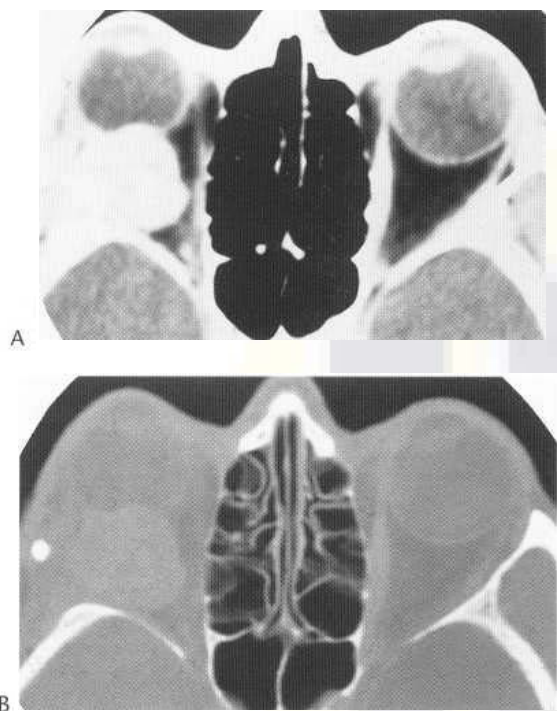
Haemangiopericytoma. Axial CT image (A) demonstrate well-circumscribed enhancing retro-orbital lesion. Bone window, (B) demonstrate erosion of adjacent lateral orbital wall.
